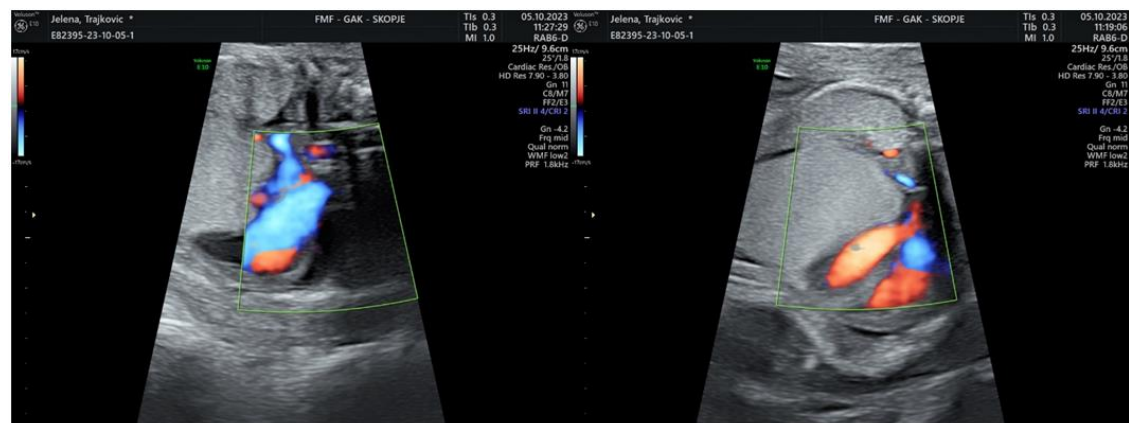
Color Doppler ultrasound
